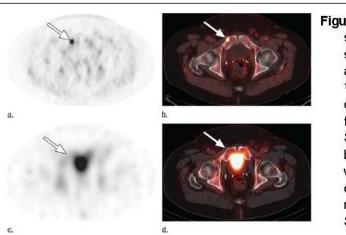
Restaging images for a patient who is status post radical prostatectomy with a serum PSA of 2.97 ng/mL. (a) Transverse anti-3-18F-FACBC PET, (b) fused anti-3-18F-FACBC PET/CT images, (c) 111In-capromab pendetide SPECT, and (d) fused 111In-capromab pendetide SPECT/CT. The arrow points to a lytic bone lesion in the right pubic ramus that was subsequently biopsy proven to contain prostate cancer. The lesion was not identified by 111In-capromab pendetide SPECT. Schuster et al, Radiology, 2011.
